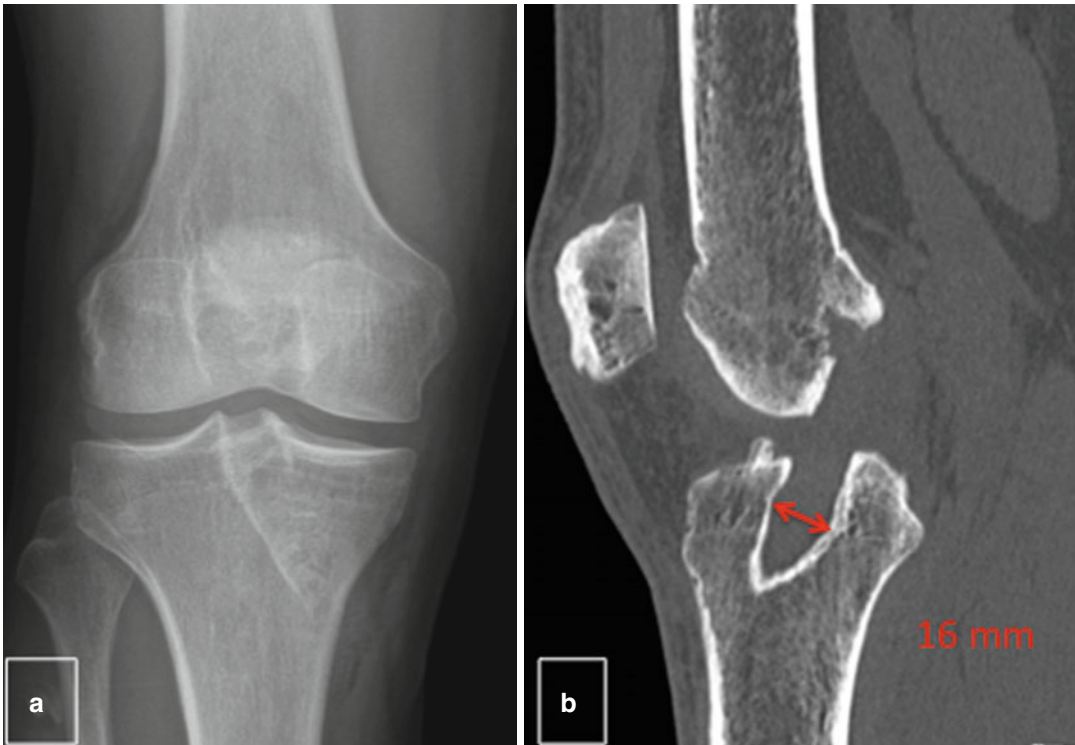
(a) X-ray and (b) CT showing a tunnel widening of the tibia >14 mm
